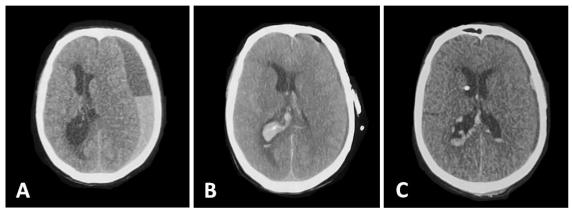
(A): CT scan showing a large left acute on CSDH with mass effect and midline shift. (B): Post-operative CT head showing subependymal bleed in the lateral ventricle. (C):Post-operative CT head three days after external drainage showing subtotal resorption of the subependymal bleed.
